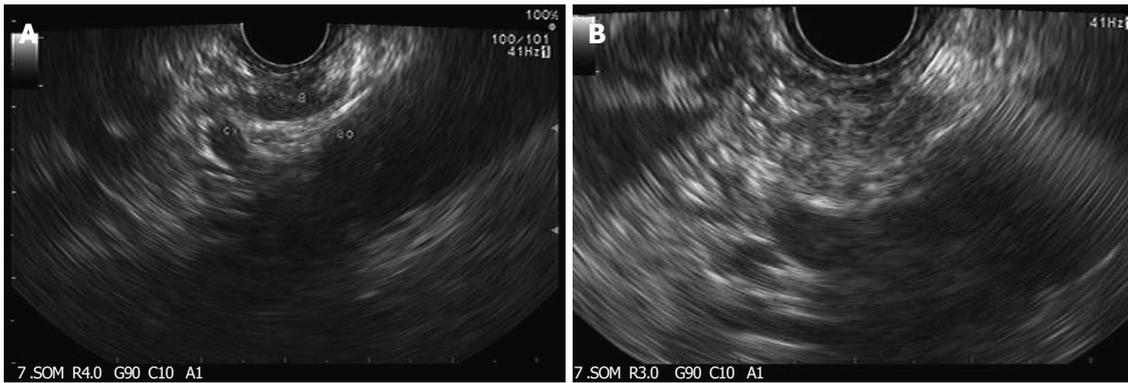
Celiac ganglia identified during endoscopic ultrasound (A) and injected during neurolysis under endoscopic ultrasound guidance (B).
